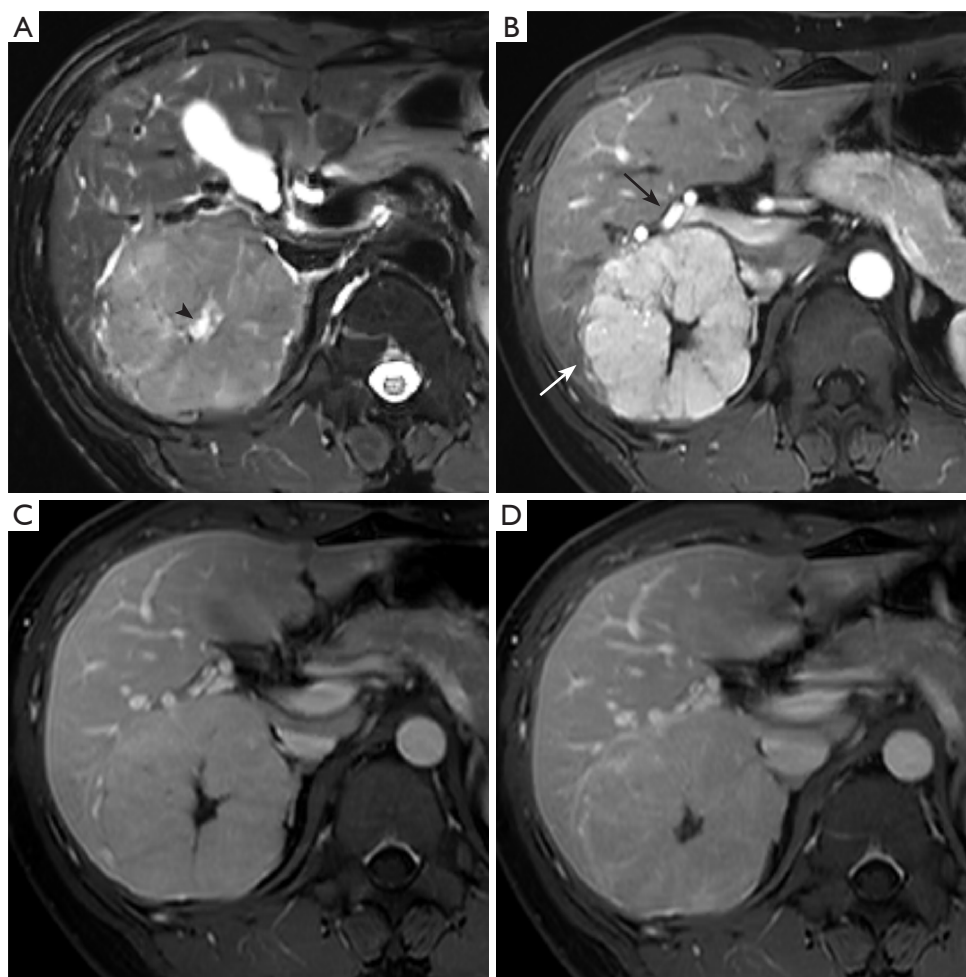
T2-weighted image (A) shows a lobulated and large FNH (8.4 cm) with central scar (black arrowhead). Arterial phase image (B) shows radiating septa (white arrow) and enlarged hepatic artery (black arrow). It shows isointense on portal (C) and delayed (D) phases. FNH, focal nodular hyperplasia.
